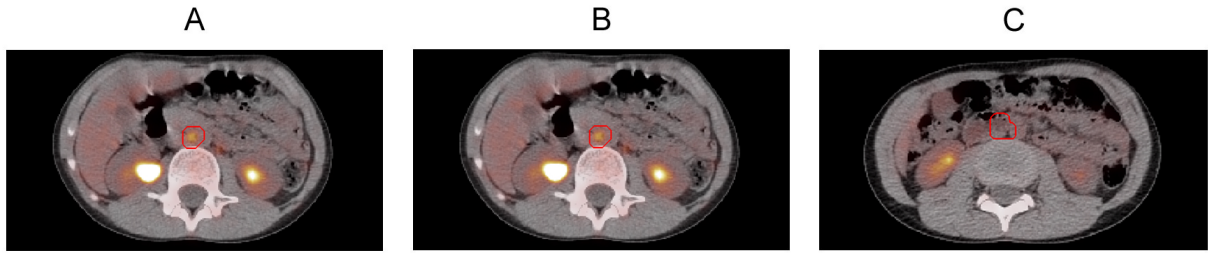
Deformable registration (with optical flow algorithm) used to deform a ROI. This ROI is superposed to fused PET/CT images of a patient with Hodgkin lymphoma. A): contoured lesion at baseline scan; B) deformed ROI at mid-treatment scan; C) deformed ROI at end of treatment scan.
